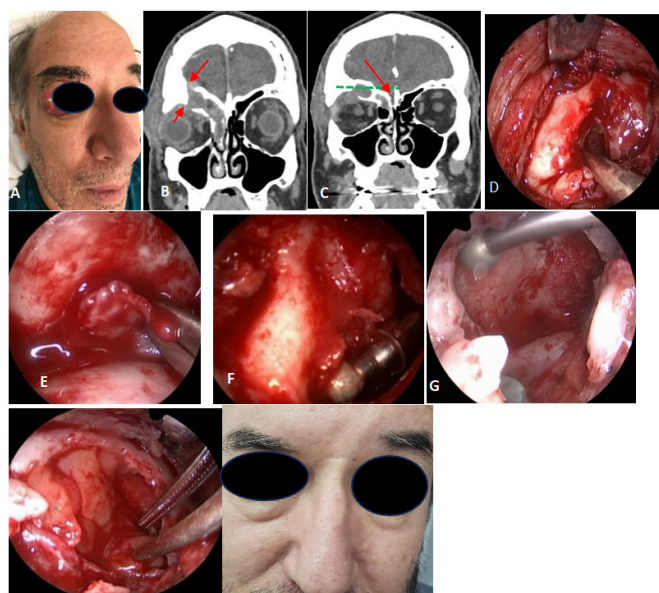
Mucocoele originating in the supraorbital cell. A: spontaneous drainage of the superior orbital abscess; B: coronal facial CT scan showing right fronto-ethmoidal opacification and erosion of the floor and superior wall of the frontal sinus, with a superior orbital abscess; C: coronal CT showing opacification of the supraorbital cell with a superior orbital abscess; D: frontal trephination via a superior transpalpebral approach; E: resection of the supraorbital cell mucosa; F-G: drilling of the supraorbital cell via the nasal route and frontal trephination; H: fat obliteration of the supraorbital cell; I: postoperative view, with no evidence of palpebral scarring
